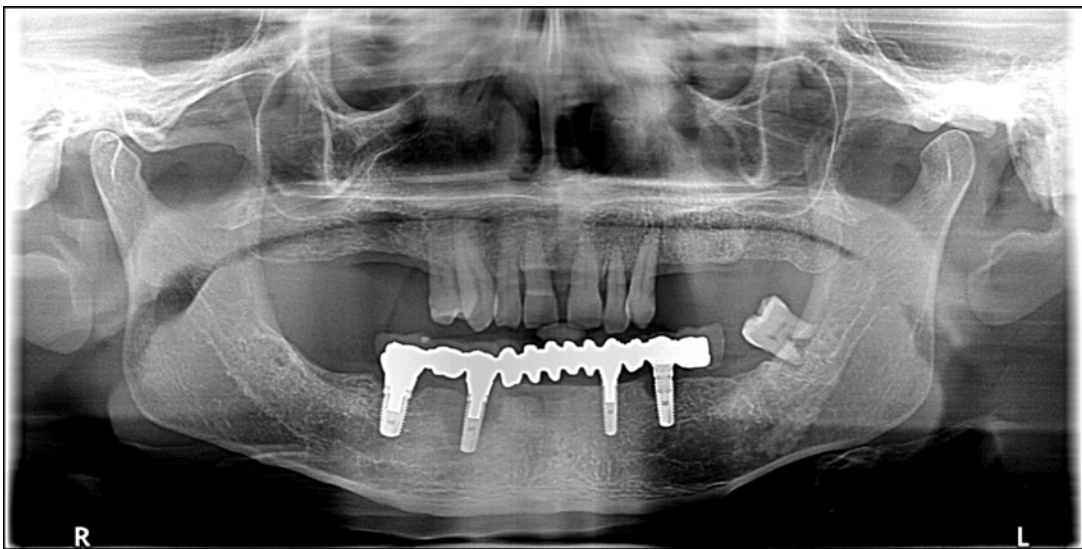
Initial panoramic X-ray showing implants with peri-implantitis and non-recoverable tooth 38
